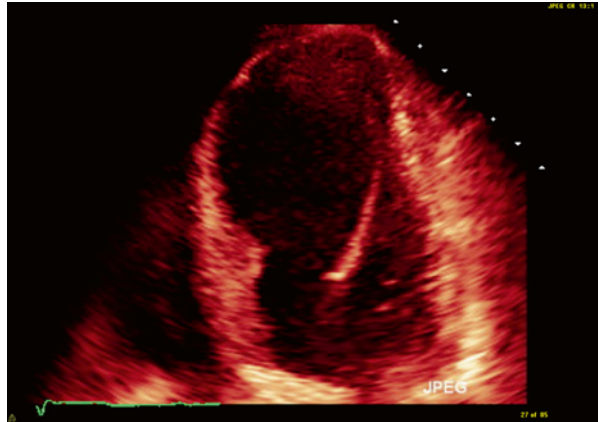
Left ventricular aneurysm on an echocardiogram
